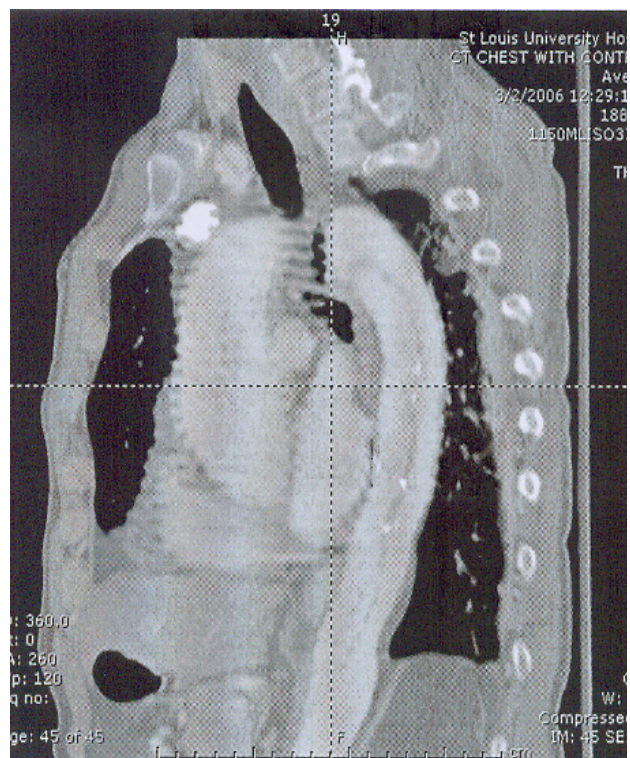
Sagittal CT scan showing retrograde dissection of arch and ascending aorta following acute descending thoracic traumatic injury (arrow).
